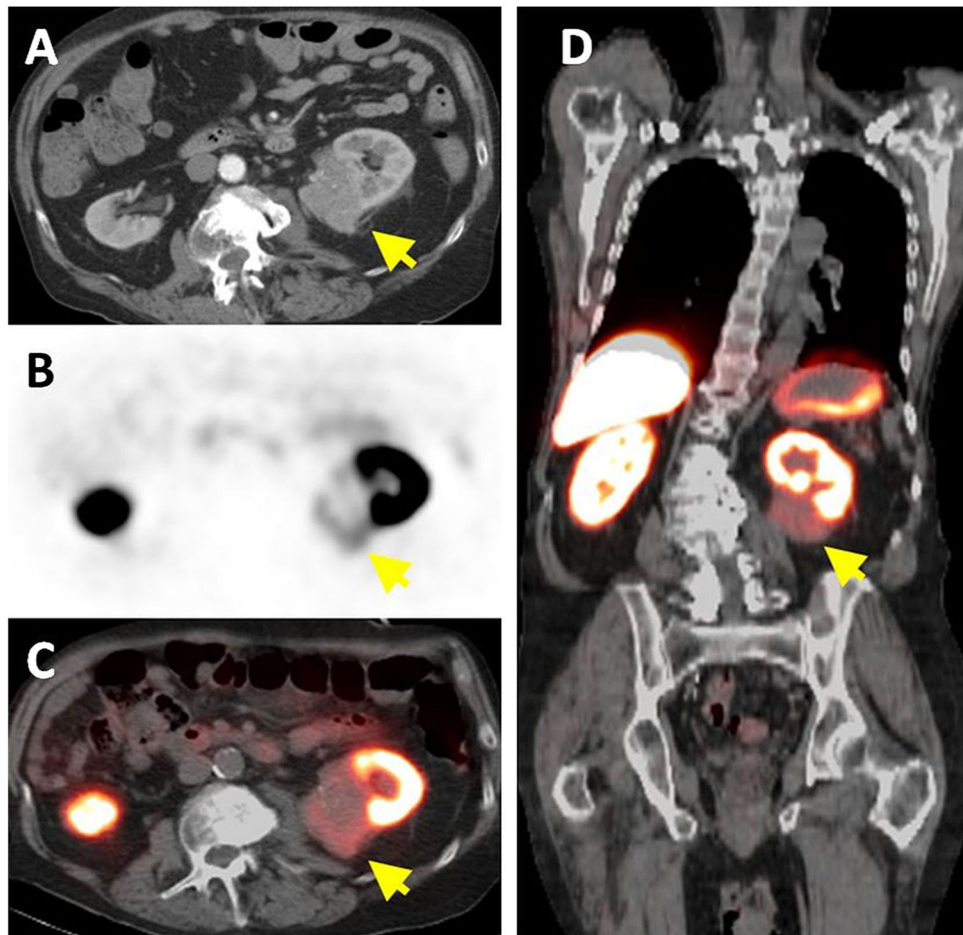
A 78-year-old man with left-sided ccRCC detected on contrast enhanced CT (*arrow*) (A). Axial ^{18}F -VM4-037 PET (B) and PET/CT (C) show uptake within the left kidney lesion (*arrow*) with an SUVmean of 1.86. Coronal ^{18}F -VM4-037 PET/CT shows the uptake within the *left* sided lesion (*arrow*) and the high uptake of the tracer in normal kidney parenchyma as well as in the liver (D).
